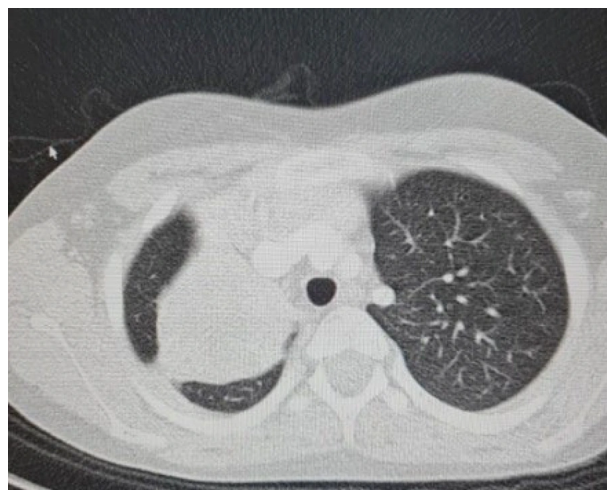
Axial CT image demonstrating a heterogeneous right upper lobe mass with central hypodensity and mild tracheal deviation, consistent with an inflammatory myofibroblastic tumor.
